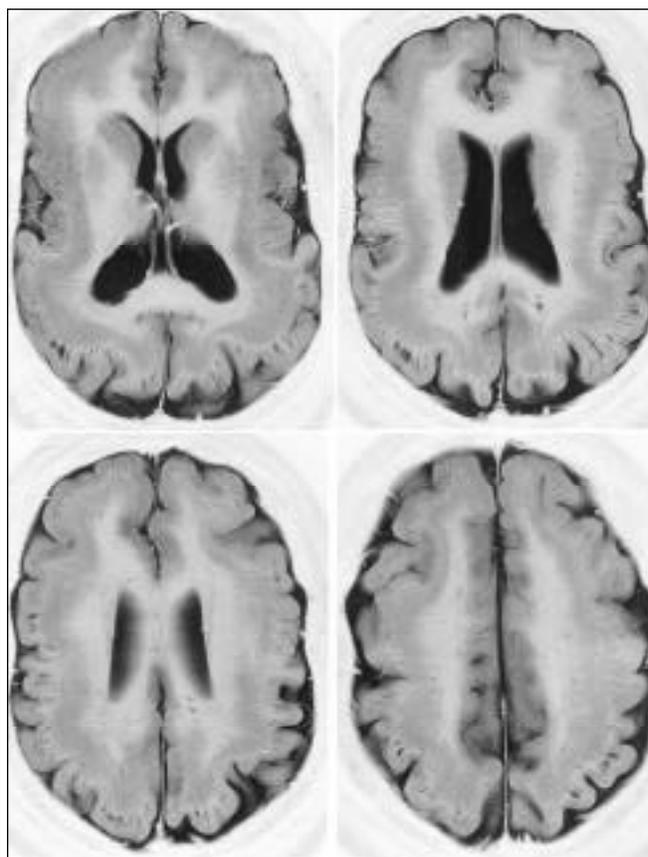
Inversion recovery MRI shows diffuse subcortical band heterotopia separated from the overlying cortex by a thin layer of white matter.
